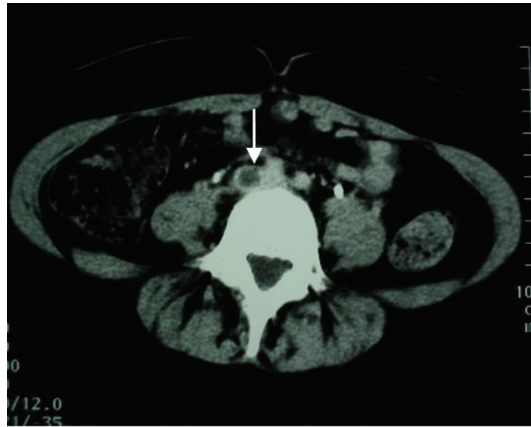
An abdominal CT scan with a clot in the right common iliac vein.
